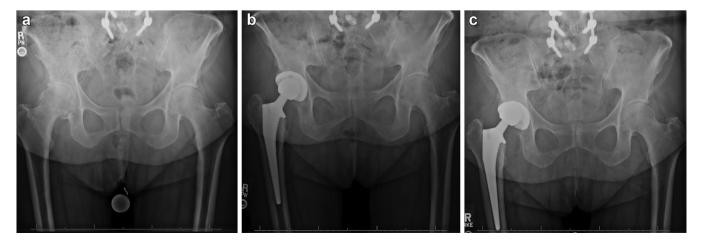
(a) Preoperative and (b) postoperative AP pelvis radiographs and (c) AP pelvis radiograph showing liner disassociation with asymmetrical position of the femoral head within the acetabular component for case 2.
